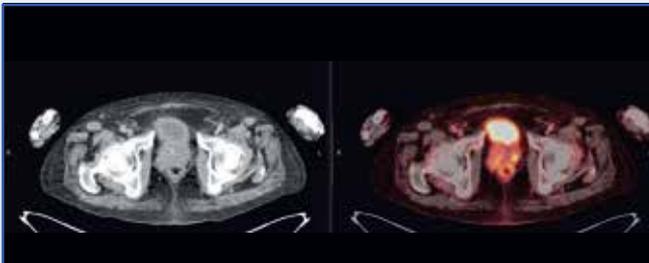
FDG PET CT displaying a subtly FDG avid nodule in the peripheral zone of the prostate along the left posterolateral aspect, suspicious of a second primary (carcinoma prostate).
